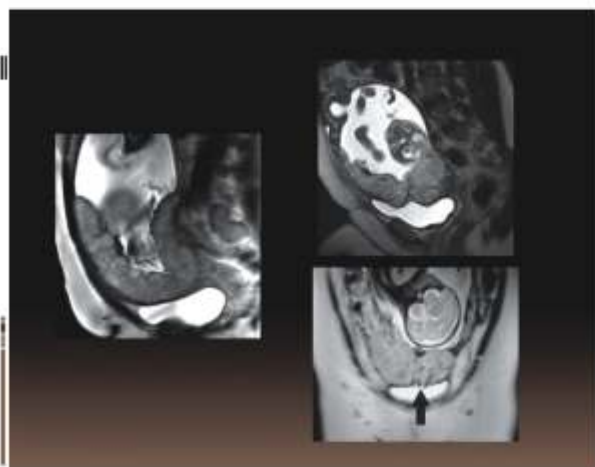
MRI showing Normal & Adherent Placenta
